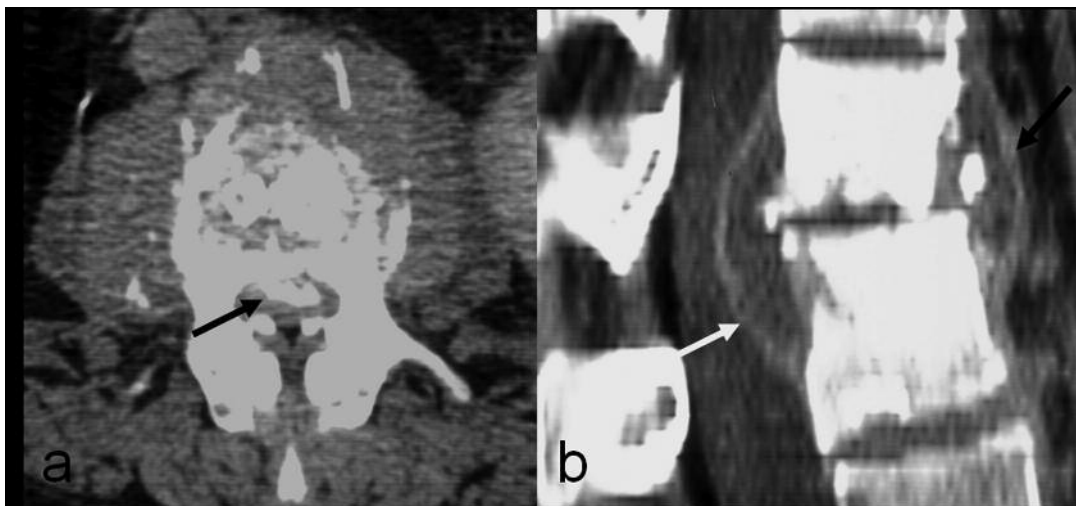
Pyogenic spondylodiscitis at L3-4 level in a 64-year-old man. (a) Axial CT scan at L3 level and (b) sagittal reconstruction CT image show destructive change with fragmentation of the vertebral bodies. Bone fragment is displaced posteriorly into the spinal canal (*arrow* in a). There is prevertebral abscess (*black arrow* in b) together with a large epidural abscess compressing the thecal sac (*white arrow* in b).
